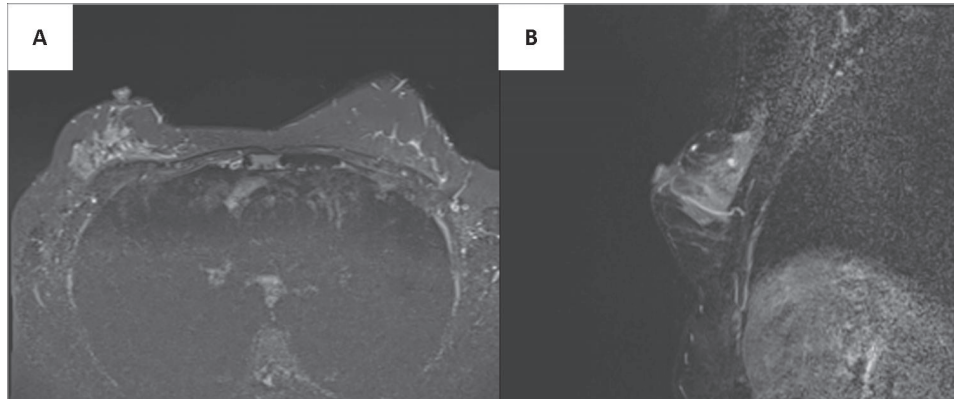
A. T2-weighted fat saturated axial MR image B. T2-weighted fat saturated sagittal MR image - Lesion with millimeter cysts approximately 2 cm from the nipple at 12 o'clock.
